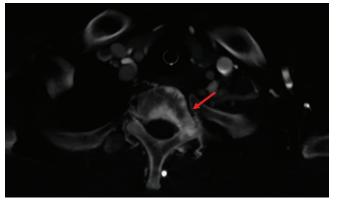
Contrast-enhanced thoracic computed tomography showed sclerotic enhancement of the T1 vertebral body (red arrow).
